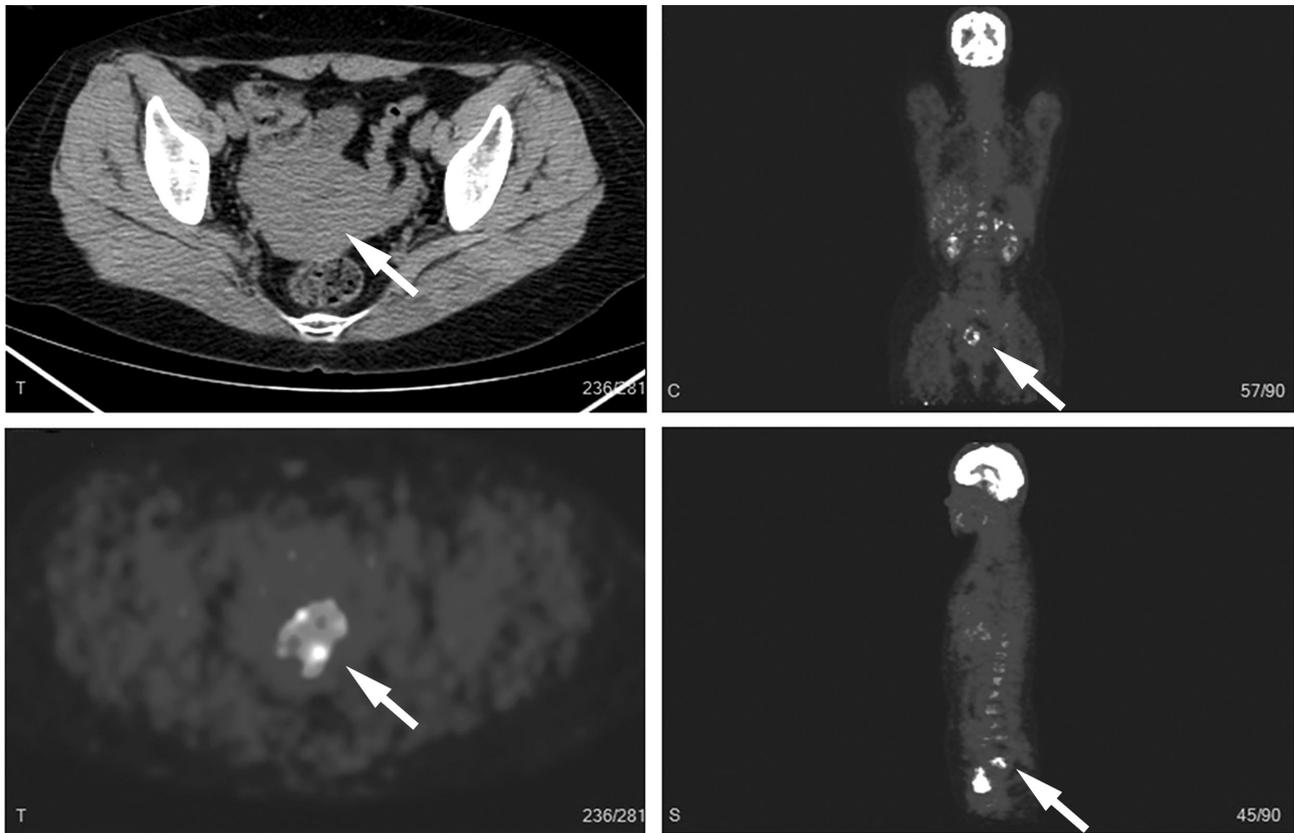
PET/CT showed that the lesion was confined to uterus (arrows) with no evidence of metastasis.
